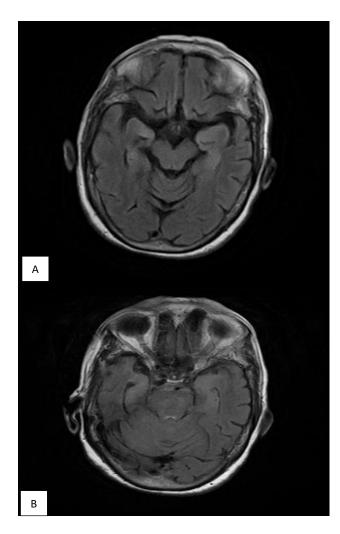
(A and B): Subtle FLAIR hyperintense signal suggestive of edema in bilateral MTL and left gangliocapsular region suggestive of encephalitis.
